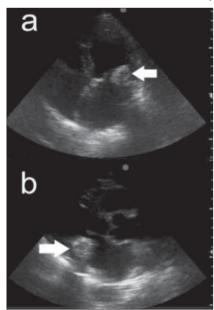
The apical (a) and parasternal (b) TTE views of a large, round, echodense mass with central areas of echolucencies attached to the posterior mitral annulus TTE-transthoracic echocardiography
